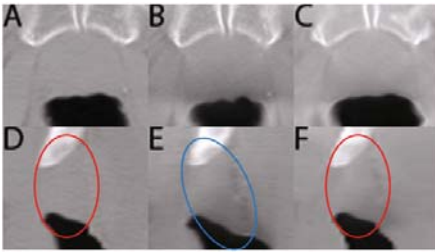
Transverse and sagittal view of the registration results in the cropped image volume around the prostate. A, D are reference CT planning data; B, E are target CBCT images; and C, F shows the registered CBCT data. In D, E, F, the prostate regions are circled out to show the motion in the Superior/Inferior direction.
